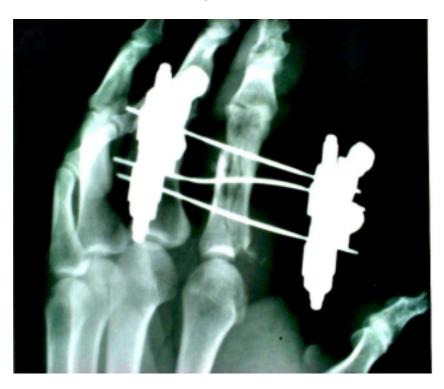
Postoperative radiograph showed a hand with a mini external fixator
